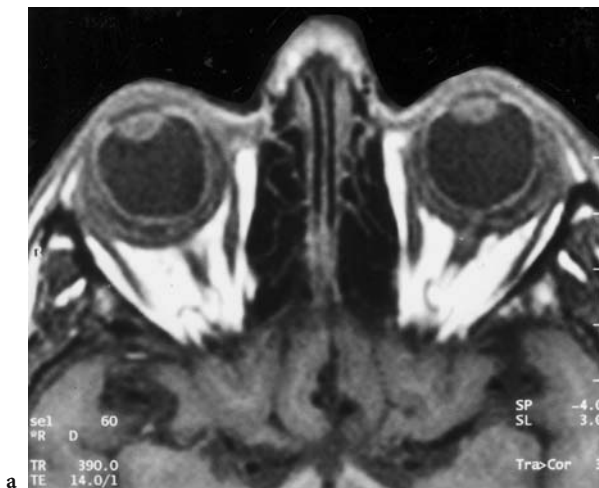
A 45-year-old woman with persistent, previously untreated, subacute, bilateral, blurred vision. Diagnosis: chronic posterior scleritis. T1-weighted MRI: a Axial view showing deformed scleral circumference of both globes and segmentation of the posterior retrobulbar space: slight crescent-shaped signal loss medial and lateral of the optic nerve; the presence of connective tissue extending from the sclera to the tendinous parts of the external muscles indicates enlargement of Tenon's capsule. b Contrast-enhanced (FS) view with demarcation of scleral inflammatory thickening of Tenon's capsule and retrobulbar inflammation. c Corresponding T2-weighted proton density image, demonstrating transformation of the fluid in Tenon's capsule, thought to be due to the persistent, untreated inflammatory process
